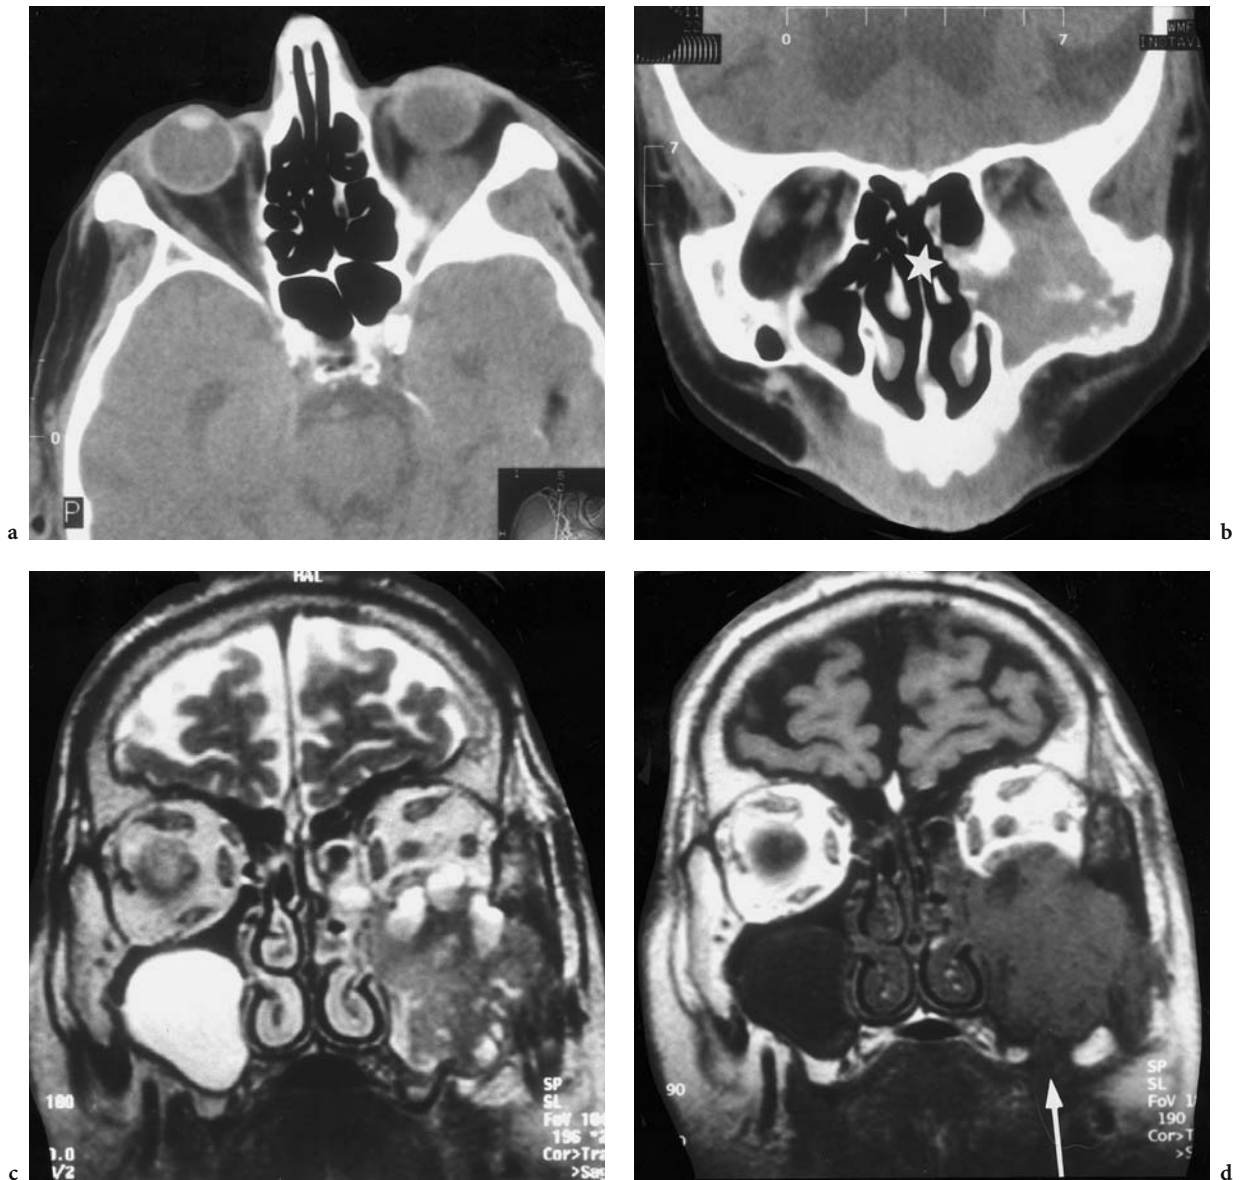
A 78-year-old man presenting with epistaxis and numbness of the left cheek. Diagnosis: carcinoma of the left maxillary sinus. CT: a Axial native view showing soft tissue in the inferior left orbit with poor distinction from the lateral rectus muscle. b Paracoronal native view, demonstrating the destruction of the maxillary sinus roof and medial wall leading to tumor invasion into the inferior orbit and nasal cavity (*white star*). MRI: c Coronal T2-weighted view with demarcation of necrotic tumor parts (high signal). Although destruction of the periorbital area might be expected, no infiltration of the inferior rectus muscle is seen. Note a maxillary sinus cyst (hyperintense) on the right side. d Corresponding T1-weighted native view identifying additional pronounced destruction of the maxillary sinus floor (*white arrow*) on comparison with c
